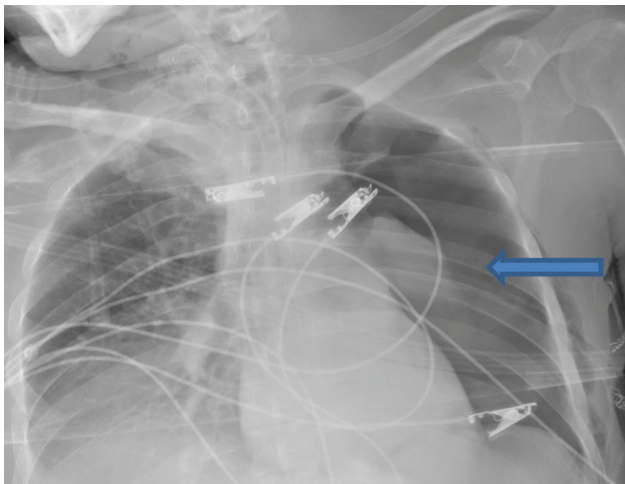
Chest X-ray showing pneumothorax (blue arrow) in patient with severe coronavirus disease 2019 and amyotrophic lateral sclerosis with intercostal drain in situ.
